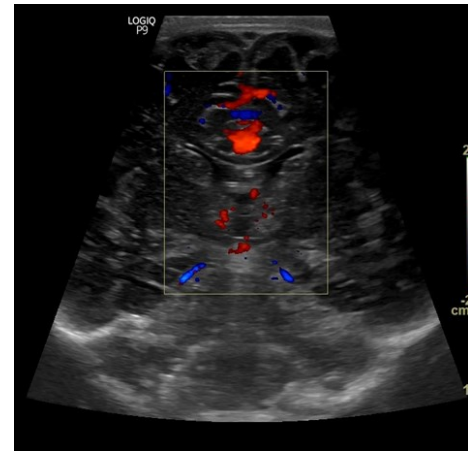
Doppler Evaluation
